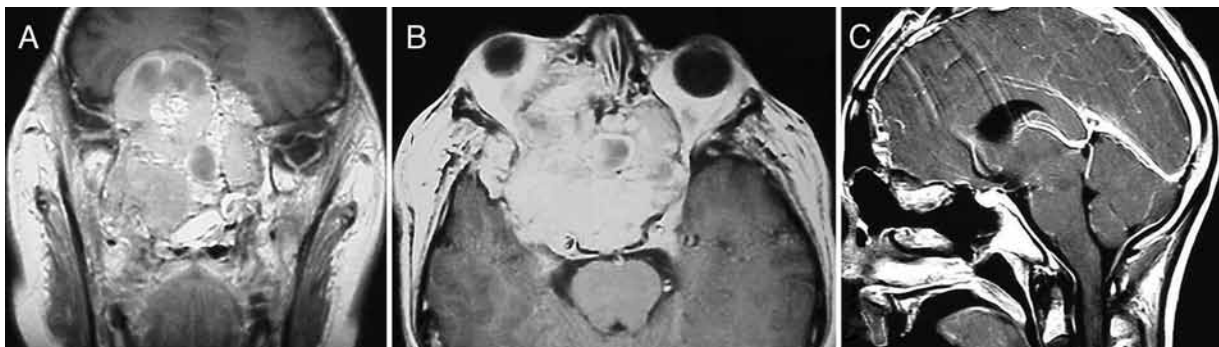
Case 5. Preoperative T1-weighted postcontrast coronal (A) and axial (B) MR images showing a giant mass lesion located in the ACF, invading the nasopharynx, paranasal sinuses, sella turcica, sphenoid sinus, and nasal cavity. Postoperative T1-weighted postcontrast sagittal MR image (C) demonstrating gross-total tumor resection.
